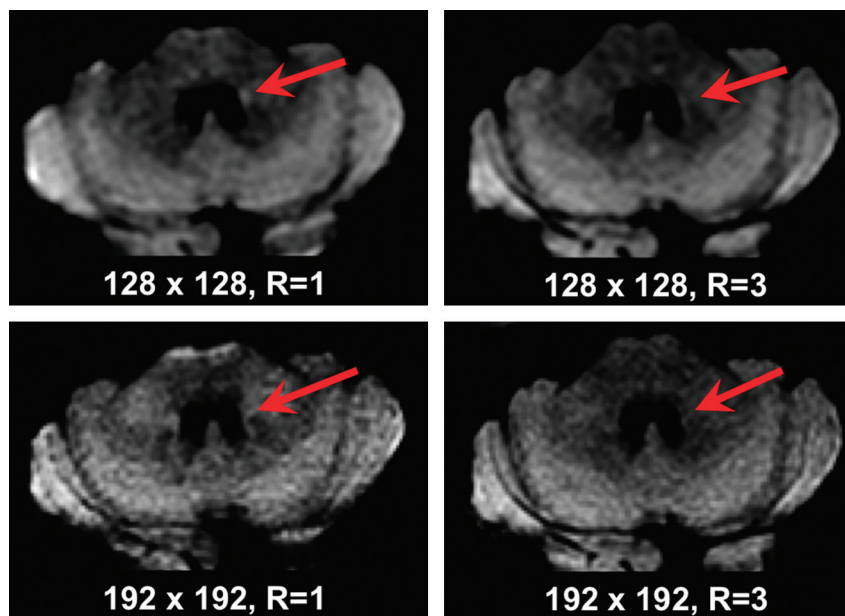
Diffusion images in a 70-year-old patient with right-sided numbness: Small acute left thalamic infarct (not shown) and tiny presumed left middle cerebellar peduncular infarct identified on the matrix = 128^2 , $R = 1$ image (*red arrow*, upper left figure), determined to be artifacts on other DWI images (upper right figure, 128^2 , $R = 3$; lower left figure. *C*, 192^2 , $R = 1$; lower right figure. *D*, 192^2 , $R = 3$) and standard MR images (not shown), altering the diagnosis from thromboembolic to lacunar infarct in 2 of 3 readers (2 of 12 DWI scan interpretations).
